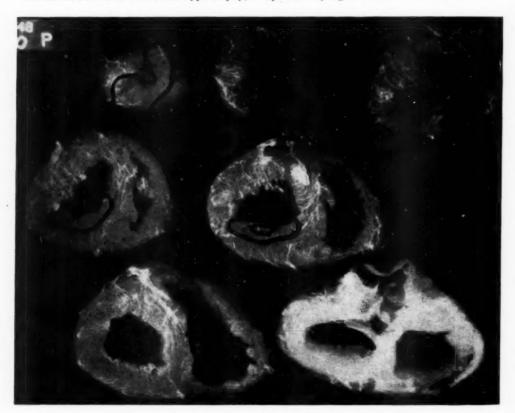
Roentgenogram of the injected heart in Case 86.
